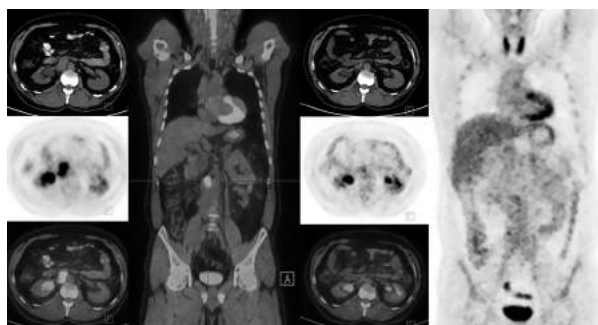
A 42-year-old man with stage IIC disease from right-sided seminoma. Initial treatment – right orchiectomy followed by chemotherapy. Referred to PET for evaluation of CT abnormality. a) First ^{18}F -FDG PET-CT scan (left part of the figure) revealed FDG-avid aortocaval lymph nodes (SUV max 11.3). b) Second ^{18}F -FDG PET-CT scan (right side of the figure), performed after chemotherapy, was normal suggesting complete response to therapy.
